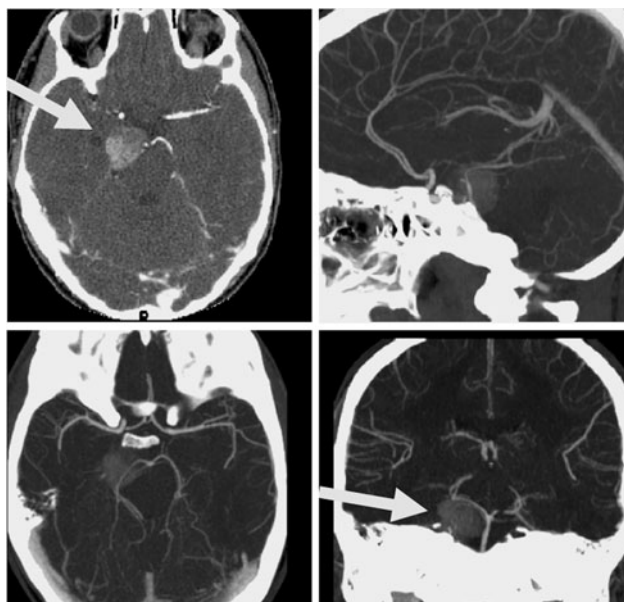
Axial CT with contrast (*top left*) with sagittal, axial and coronal MIP reconstructions demonstrate an enhancing right CPA mass without evidence of giant aneurysm
